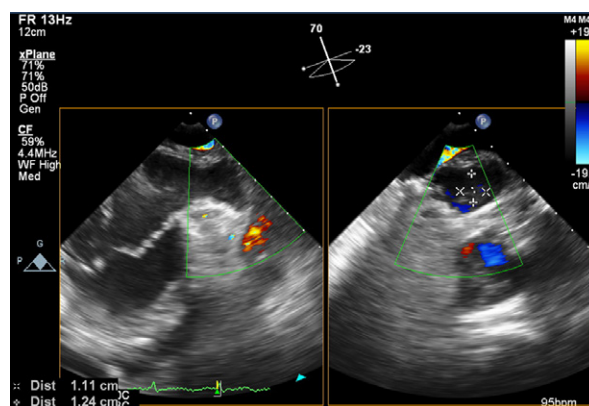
Transesophageal echocardiogram shows a 1.11×1.24 -cm thrombus in the left atrial appendage cavity.
